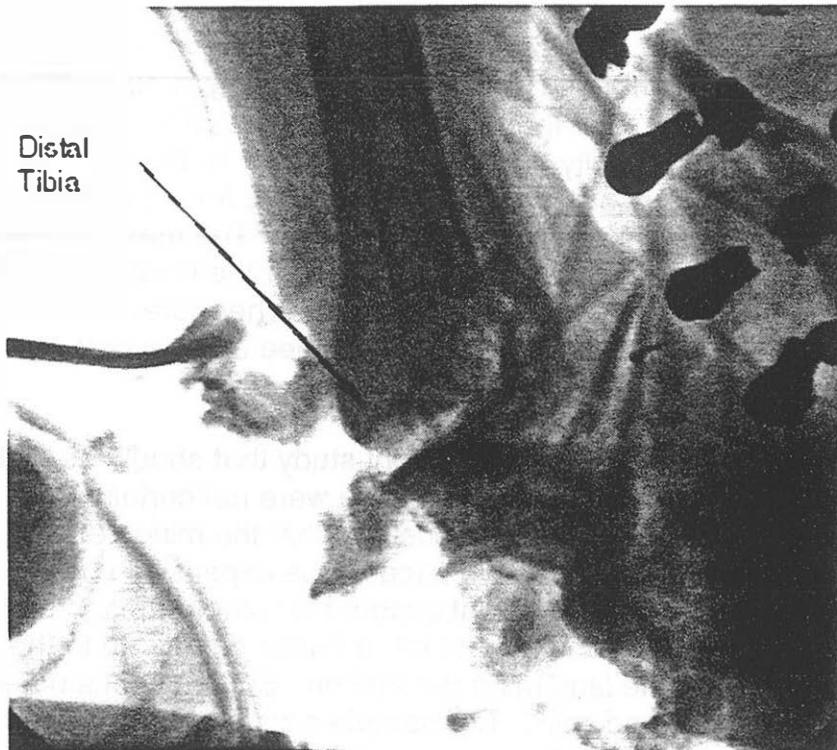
A radiograph showing typical damage to a foot that results from landmine detonation with a standard combat boot. The distal portion of the tibia is the only recognizable structure.
